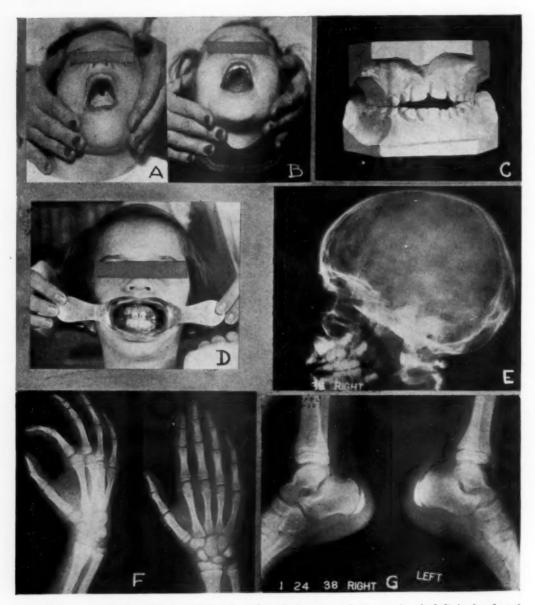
A, Perforation remaining in palate before secondary repair of cleft in hard and soft palates. B, Perforation in palate closed after secondary repair operation. (Courtesy of Carl G. Burdick, M.D.) C, Models showing open-bite before treatment. D, Showing progress with opposing teeth now in contact. E, Profile x-ray photograph of skull appears to be negative. F, X-ray photograph of wrist shows normal osteogenetic development. G, X-ray photograph of ankle showing normal osteogenetic development.
